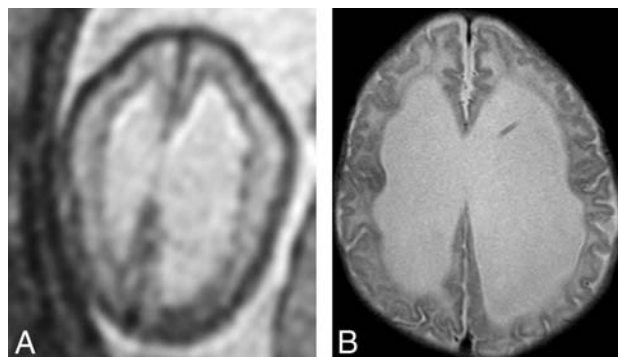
An example of subependymal nodularity giving the false appearance of SEH (false-positive finding). Axial T2 single-shot fast spin-echo image from fetal MR imaging at 24 weeks' GA (A) demonstrates nodularity along the ependymal surfaces of the lateral ventricles, giving the appearance of SEH. However, postnatal MR imaging at 8 weeks of age (B) does not demonstrate any SEH.
